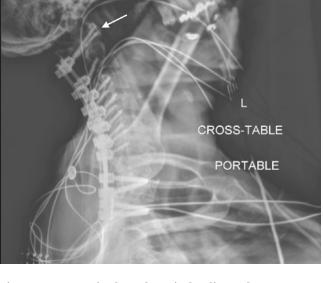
Postoperative lateral cervical radiograph, "Swimmer's view," depicting placement of the posterior instrumentation from C1-T2. Area of interest at C1 anterior arch (white arrow).
